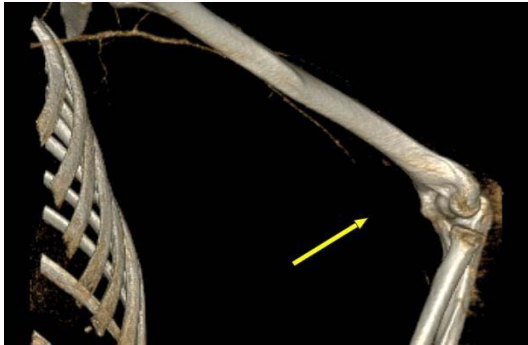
3D reconstructed CTA of an unopacified, unvisualized, segment of the left brachial artery concerning for transection versus thrombosis.
